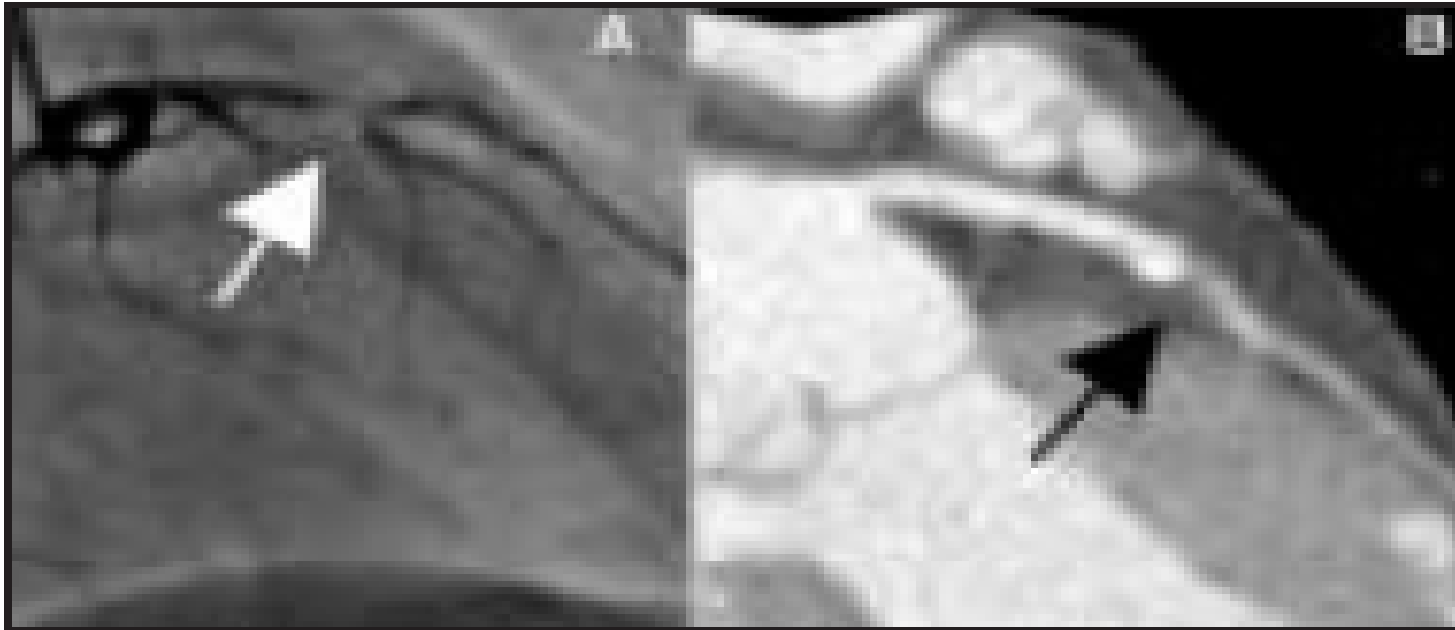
High-grade stenosis of the left anterior descending artery (arrows) visualized by invasive coronary angiography (A) and CTA (B).
